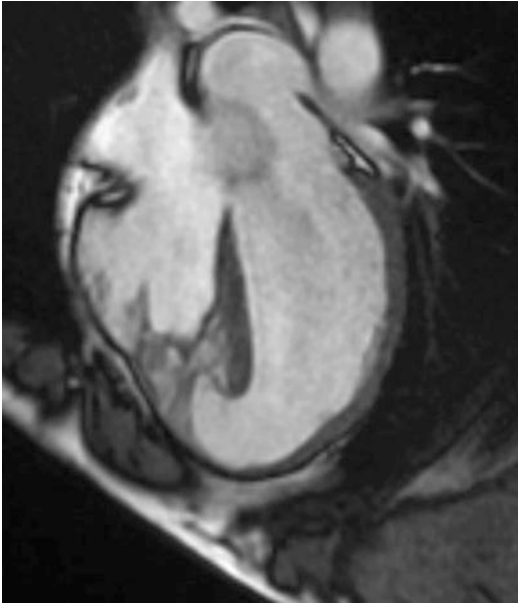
CT angiography demonstrating DCRV with apical VSD
